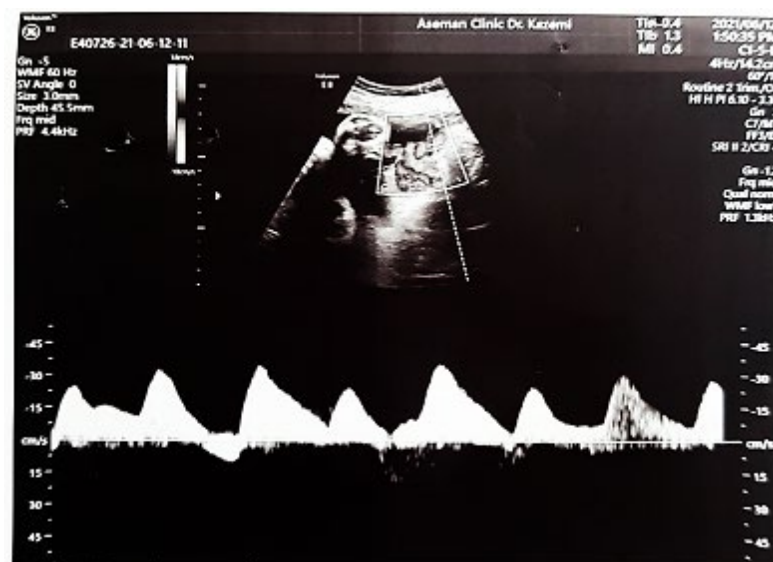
Doppler ultrasound study increased PI and RI of uterine arteries
